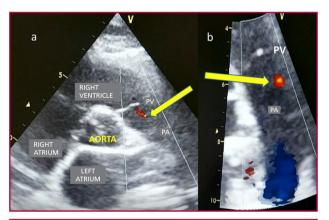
Color-Doppler echocardiography image. Short axis view of large vessels (a). The arrow targets a small color flow jet on the pulmonary artery (PA) trunk at 4 mm from the pulmonary valve (PV) plane, which does not seem to have regurgitation (b).
